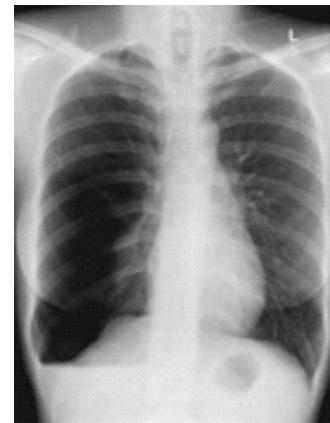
Plain chest radiograph result
